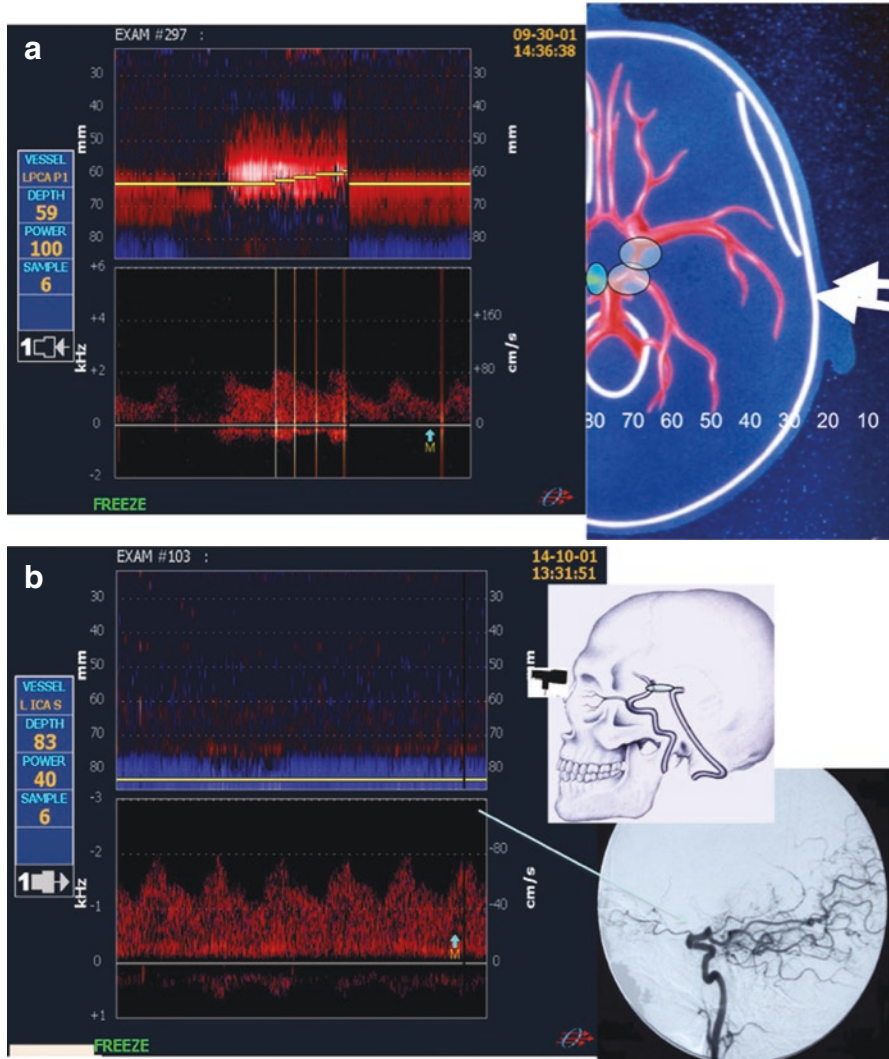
Posterior Communicating Artery signature (PcomA) on Transcranial Doppler and Power M Mode Doppler: Panel (a) PcomA signature through the temporal window at depth 50–60 mm (Stenotic signal toward the probe on the affected side); Panel (b) Retrograde PcomA Signature through the orbital window in the presence of terminal internal carotid artery occlusion (Stenotic blue signal at depth >80 mm)
